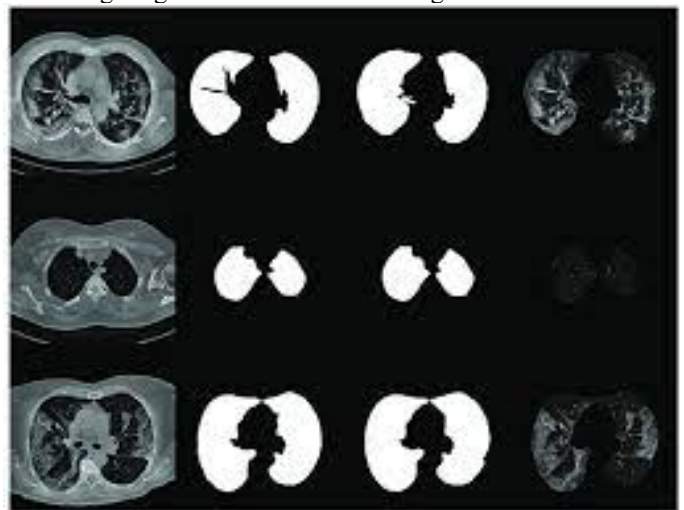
Lung MRI Image Segmentation
